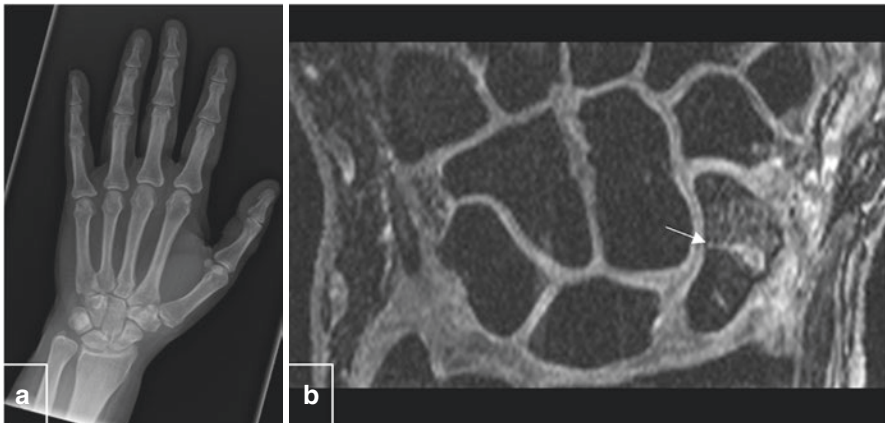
AP radiograph of the wrist (a) showing a normal scaphoid in a patient with anatomical snuffbox pain following a fall. Coronal MRI image of the wrist (b) demonstrates an un-displaced fracture of the scaphoid waist (arrow), not visualized on the preceding radiograph. (Images courtesy of Dr. Ganesh Retnasingam MBChB, MRCSEd, PGCMEd, FRCR, Consultant MSK Radiologist, Liverpool University Hospitals NHS Foundation Trust)
